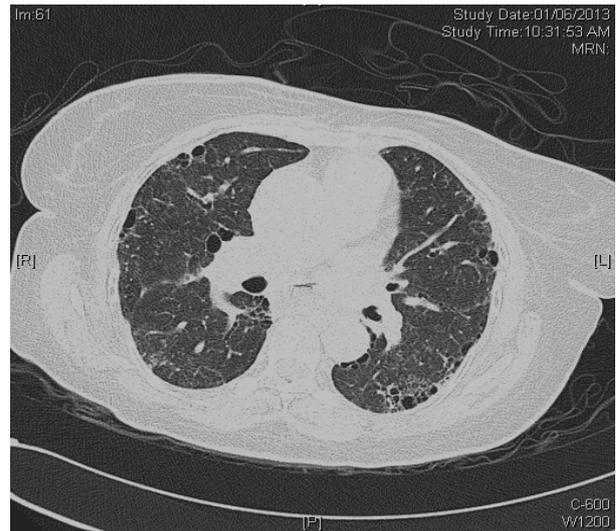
High resolution CT Chest June 2013 showing stable lung fibrotic changes.
